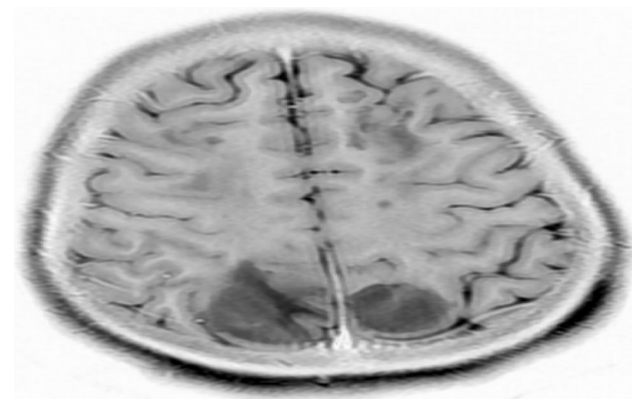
MRI of the brain, axial view—high signal intensity involving the cortex and subcortical white matter of both occipital lobes
